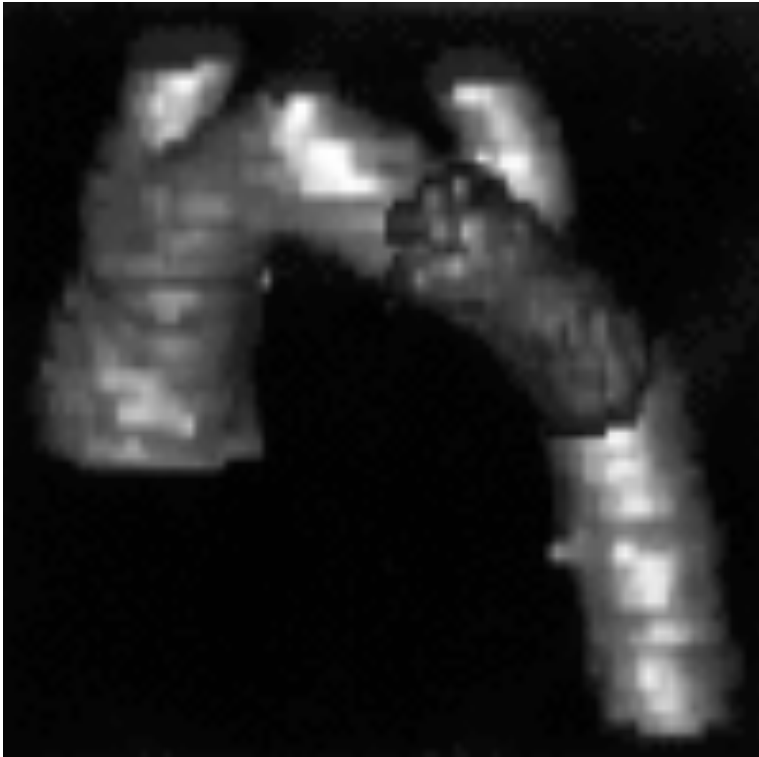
Three dimensional reconstruction of spiral computed tomography images with contrast taken nine months after stent implantation in the patient shown in Fig. 1. The stent has been outlined in a different shade of grey from the aorta. Note continued patency of the left subclavian artery.
